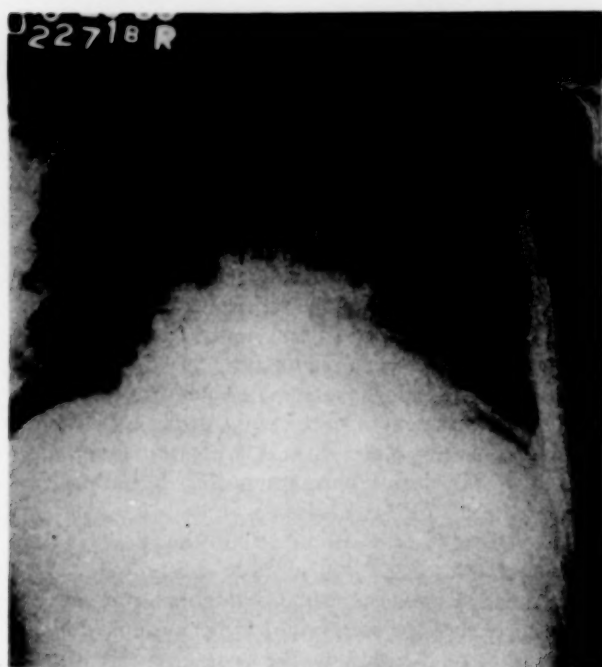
X-ray taken two weeks after completion of radiation therapy, Case iv.
